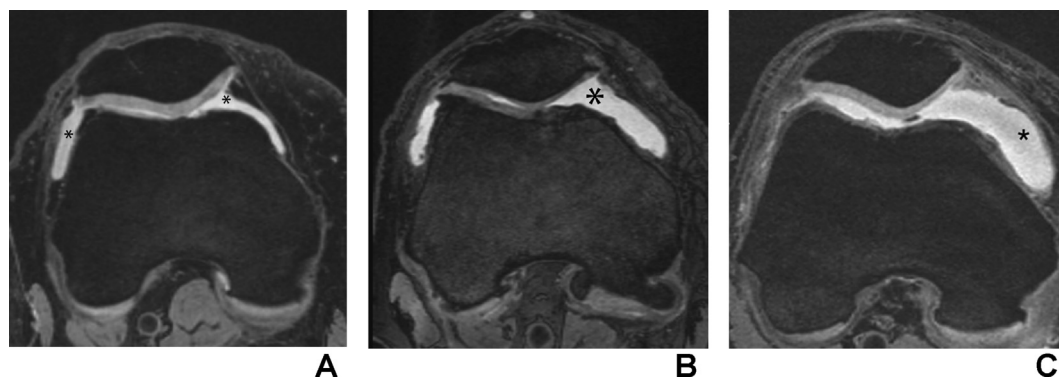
Effusion-synovitis on MRI is defined by the amount of capsular distension on axial fluid-sensitive sequences; A. Grade 1 effusion-synovitis is shown on this axial image is depicted as intra-articular fluid-equivalent signal (asterisks). B. Grade 2 effusion-synovitis is shown representing a moderate amount of capsular distension (asterisk). C. A large amount of distension is defined as grade 3 effusion-synovitis (asterisk). Note that intra-articular joint fluid cannot be differentiated from synovial thickening that also appears hyperintense on T2-weighted images.
